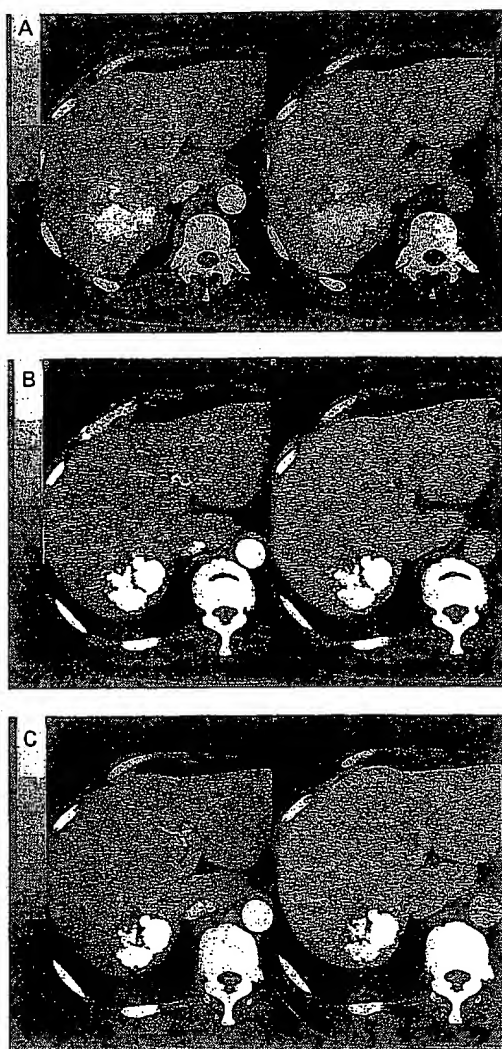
Early and late phases of dynamic CT of liver of a hepatocellular carcinoma patient who had received Antineoplaston AS2-1 treatment. CT taken 3 months after the first incomplete TAE (A), CT taken 13 months after TAE (B), CT taken 20 months after TAE (C). A gradual reduction of viable lesion was observed.
